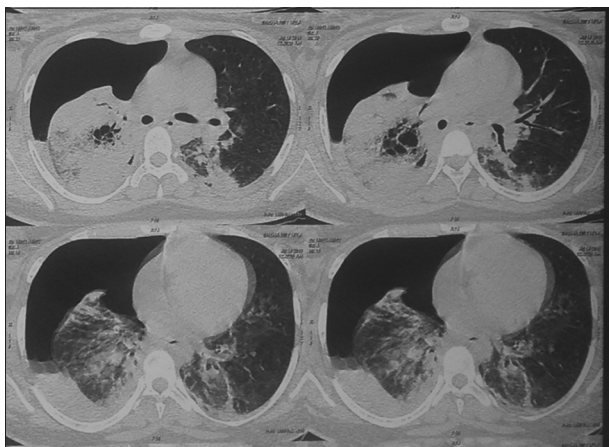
HRCT chest showing right side hydropneumothorax with cavity and collapse of underlying lung
